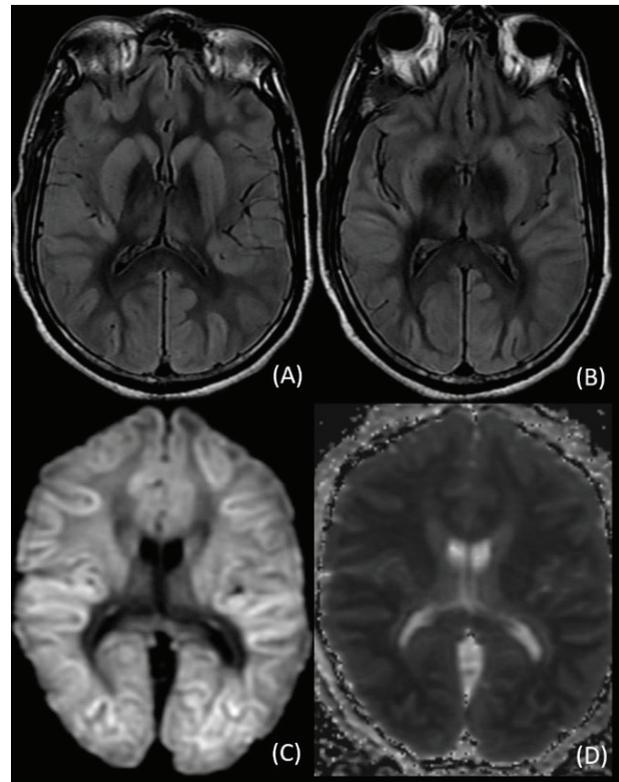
MR images of a RT-PCR SARS CoV-2 positive 40-year-old male show hyperintensities in bilateral caudate nuclei, putamina, globi pallidi, substantia nigra, parietal and temporal cortices on T2W (A and B) and FLAIR images (C and D); consistent with severe hypoxic encephalopathy.
